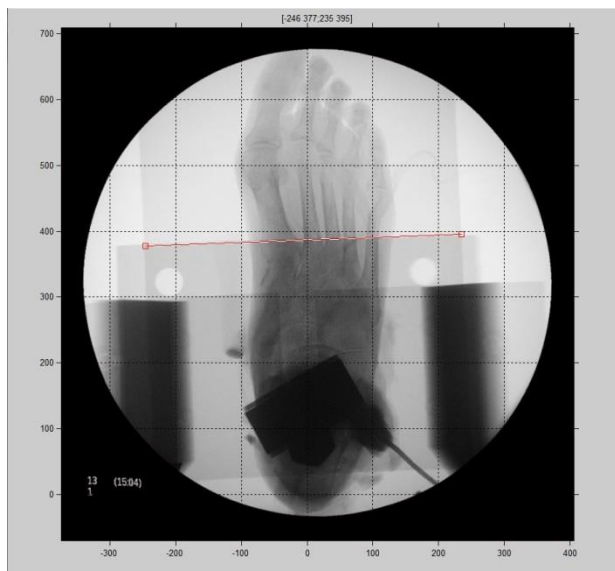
The line in the image rescale figure is aligned with the scale-bar (in this example the width of the x-ray loading fixture was used, which, some would say this makes for a *less than ideal* scale bar).
